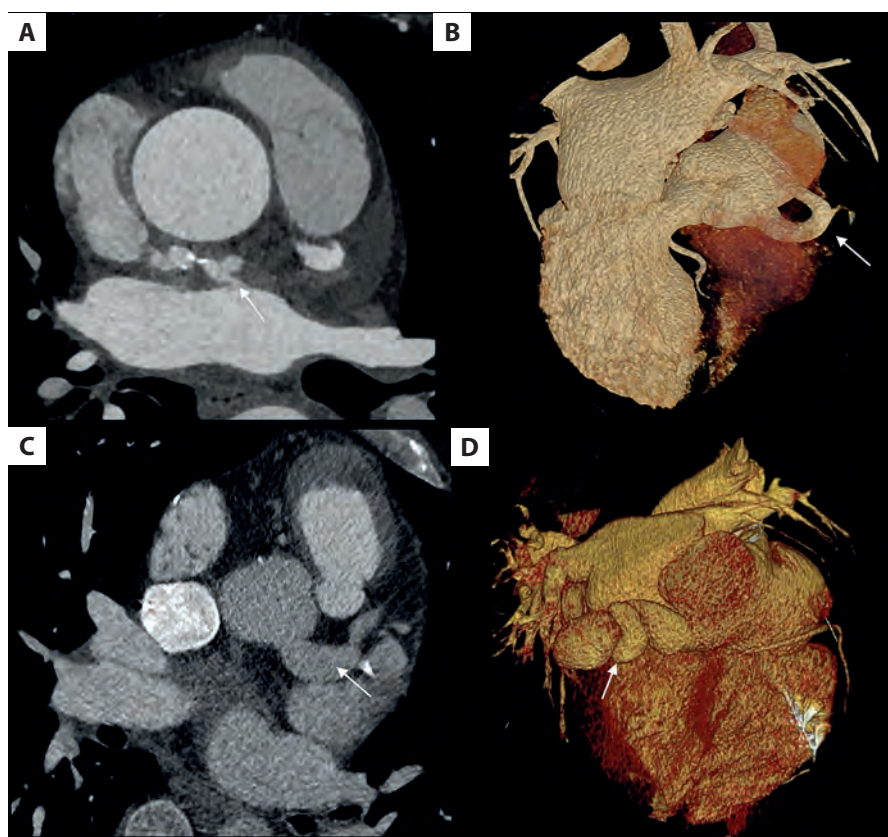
Coronary CT. A. MPR. B. Volume-rendered reconstruction, CAF between the RCA and the left atrium (white arrows). C. MPR. D. Volume-rendered reconstruction, CAF between the circumflex artery and the coronary sinus (white arrows)
